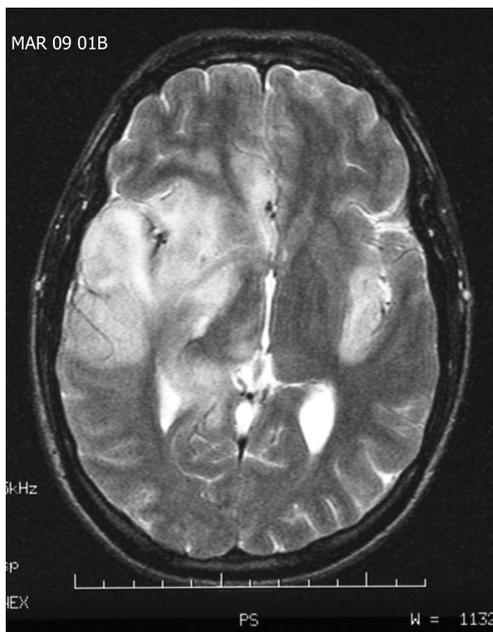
HSE 12 days after onset, T2 weighed MRI.
